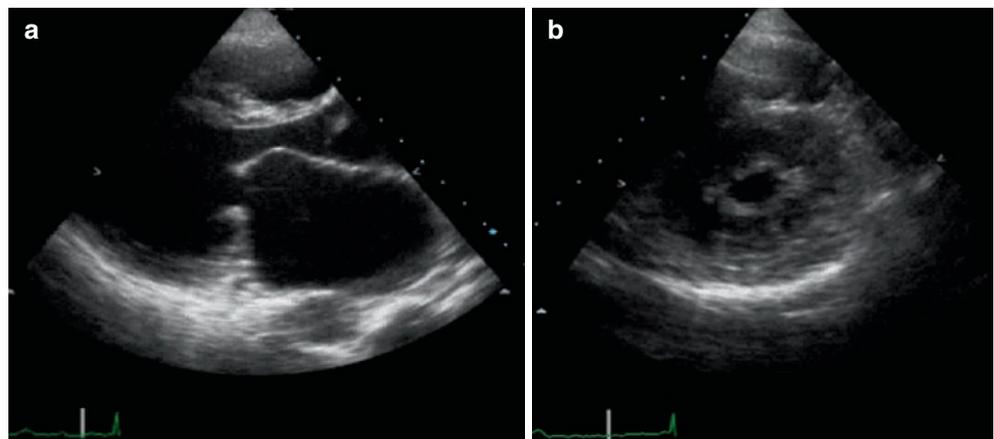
Typical example of rheumatic mitral stenosis (parasternal views). (a) Parasternal long-axis view with typical diastolic doming of the anterior mitral leaflet and anterior displacement of the posterior leaflet. (b) Parasternal short-axis view showing the mitral valve orifice
